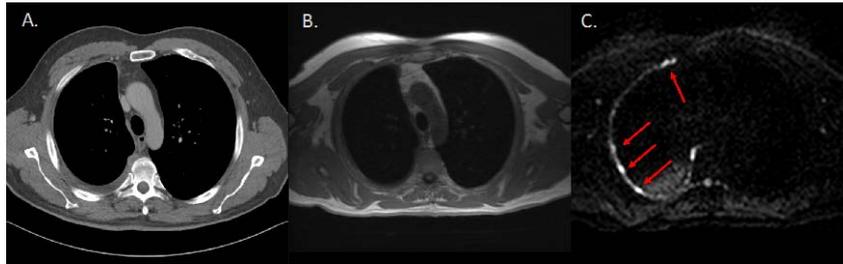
A 60-year-old man with right-sided MPM. (A.) CT and (B.) T1-weighted MRI show right-sided pleural thickening with shrinking lung sign. (C.) DWI ($b = 800 \text{ s/mm}^2$) shows a sign of pointillism such as multiple speckled hyperintense pleural spots (red arrows), which are most likely caused by small multifocal deposits of tumours.
